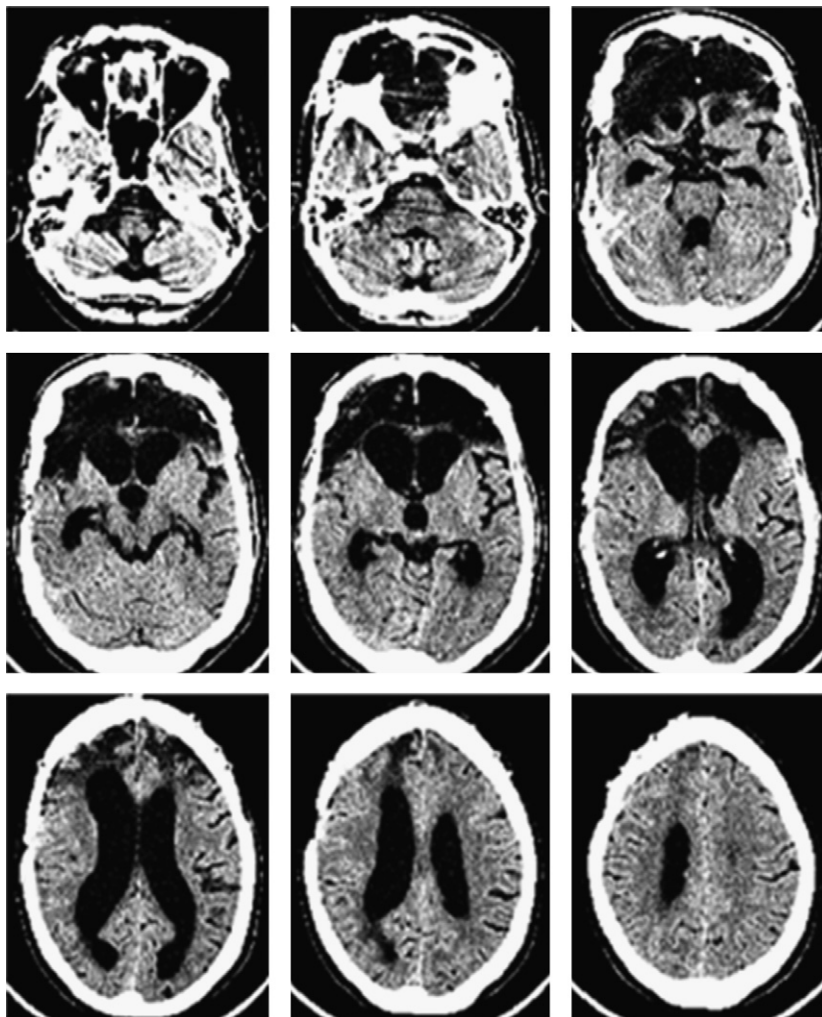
CT image (axial slices) of patient experiencing depression alleviation following suicide attempt. Ventral PFC is almost entirely destroyed, including vmPFC bilaterally (top row), whereas dorsal PFC is largely intact (bottom row).
